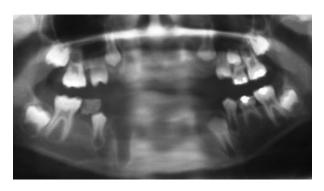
Panoramic X-ray of a 9-year-old boy who avulsed nine permanent teeth after falling on his face to a metal pipe.
